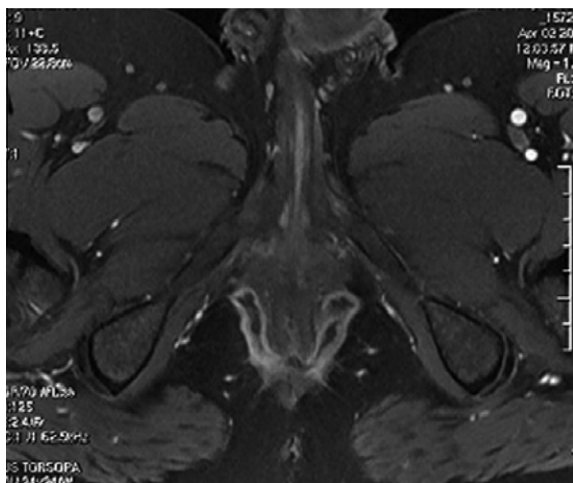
Axial contrast enhanced fat suppression MRI revealed bilateral saddle shape perianal fistula with acutely inflamed enhancing margins. The shape of fistula and bilateral involvement is characteristic of Crohn's disease.
